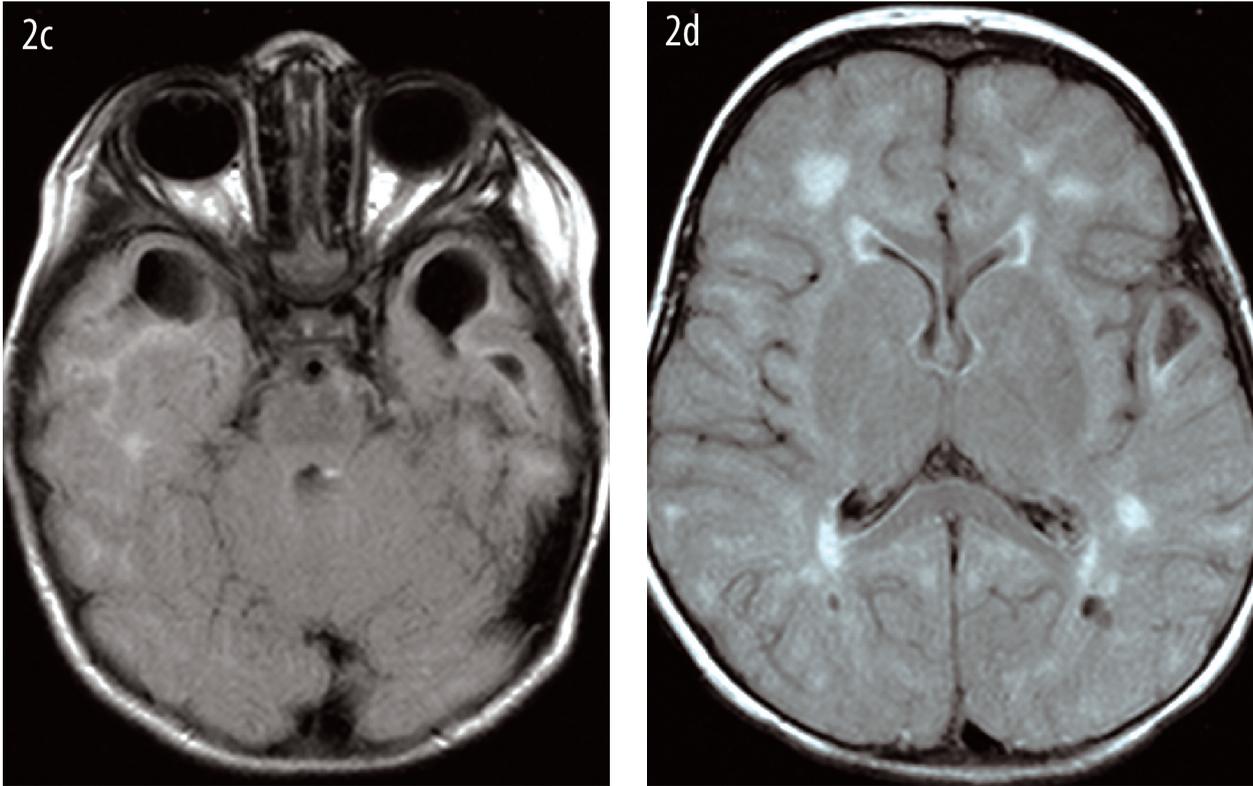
FLAIR sequence axial images show cystic lesions in anterior temporal which are isointense to cerebrospinal fluid (CSF)
